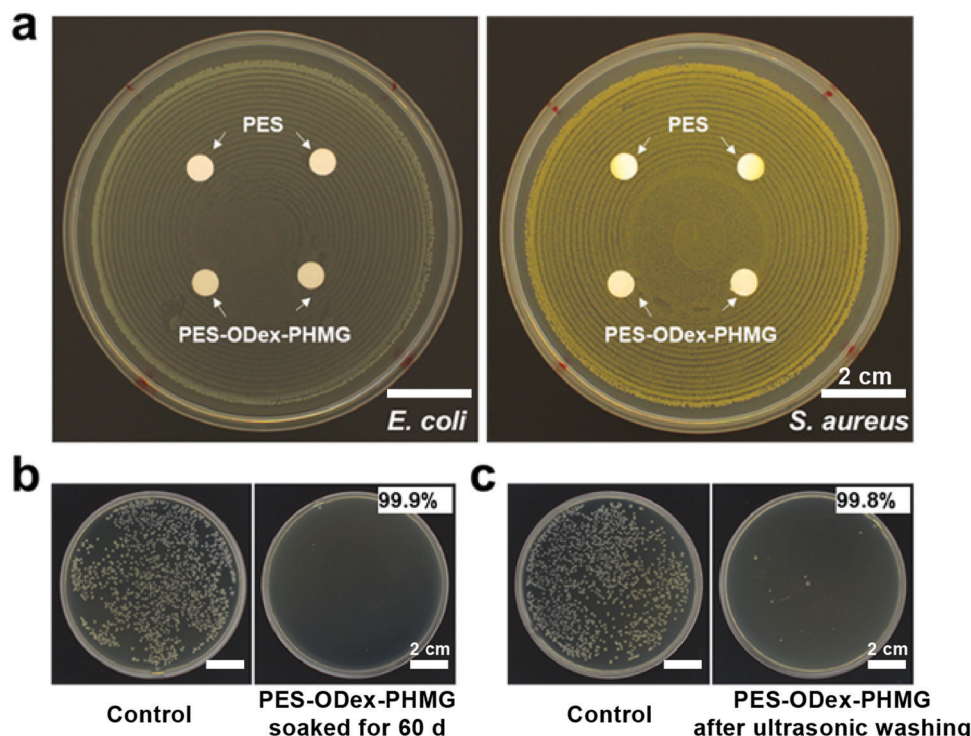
(a) The inhibition zones of PES and PES-ODex-PHMG; (b) filtration efficiency of PES-ODex-PHMG driven by gravity after being soaked in water for 60 days; (c) filtration efficiency of PES-ODex-PHMG driven by gravity after being washed by ultrasonication.
